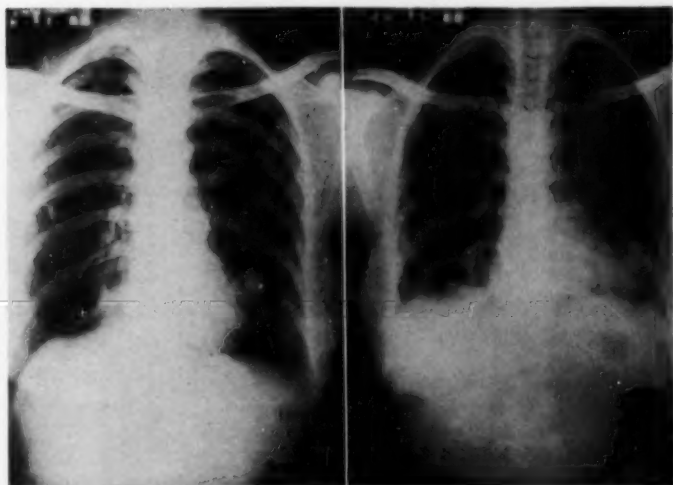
Radiographs taken during forced expiration, on the left, and inspiration with the upper airway closed, on the right.
